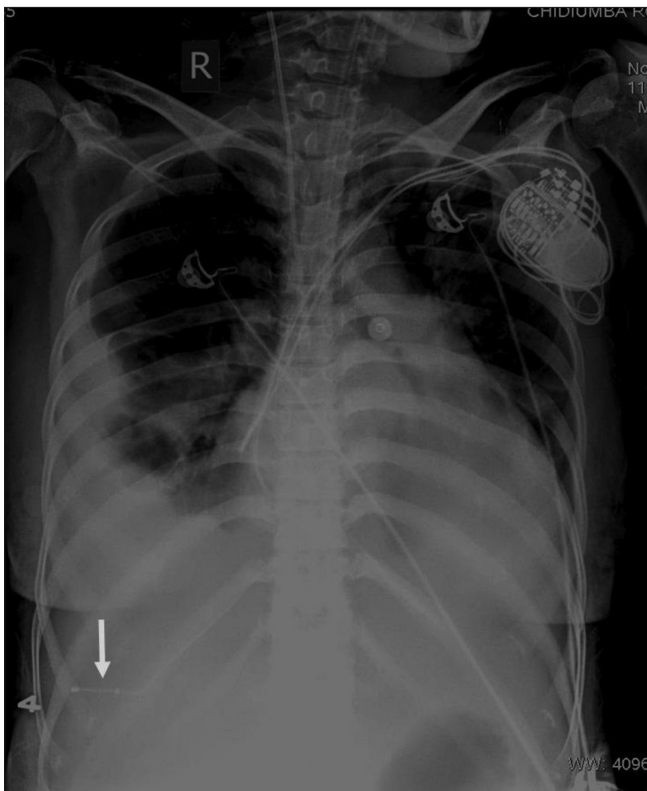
Frontal chest radiograph shows abnormal course of the lead with the electrode tip overlying the liver (arrow). This was due to cardiac perforation by the pacemaker lead, with a fatal outcome
